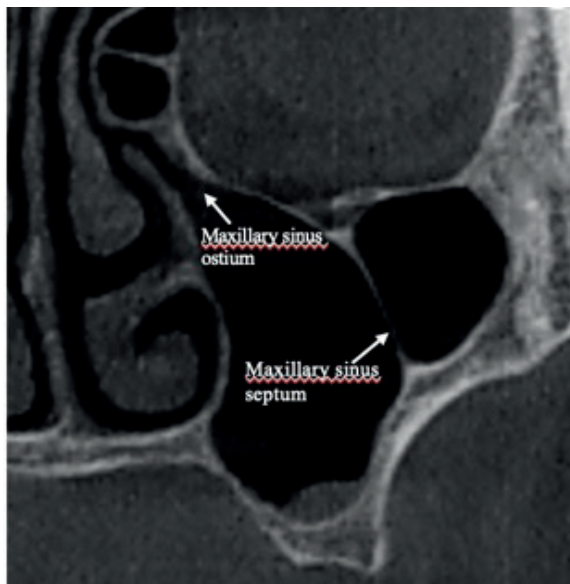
CBCT coronal section showing ostium of the maxillary sinus and septa of the maxillary sinus
